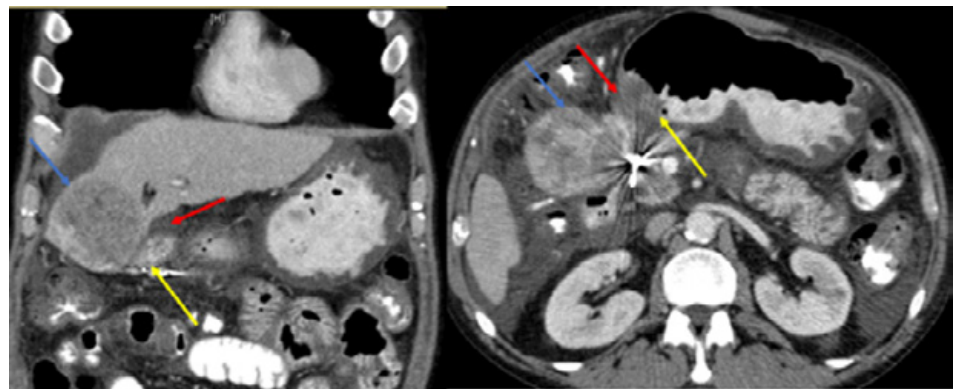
Coronal (left) and axial (right) Computed tomography (CT) of the abdomen and pelvis showing 7.3 cm segment IV HCC mass (blue arrows) eroding into the duodenum (yellow arrows) with associated mass effect and hemoperitoneum (red arrows).
